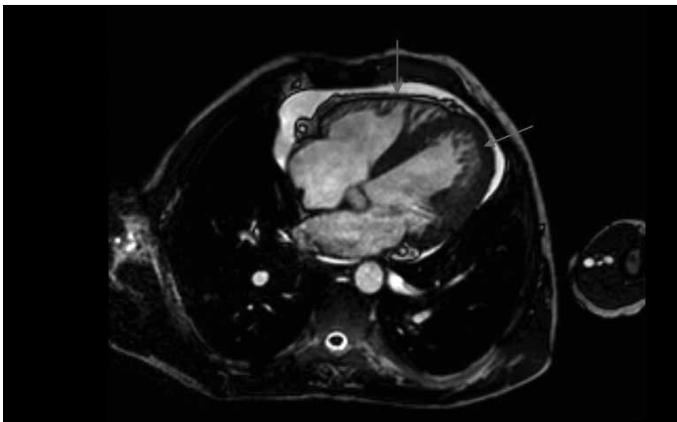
Cardiac magnetic resonance imaging of the patient confirming the findings of transthoracic echocardiography
